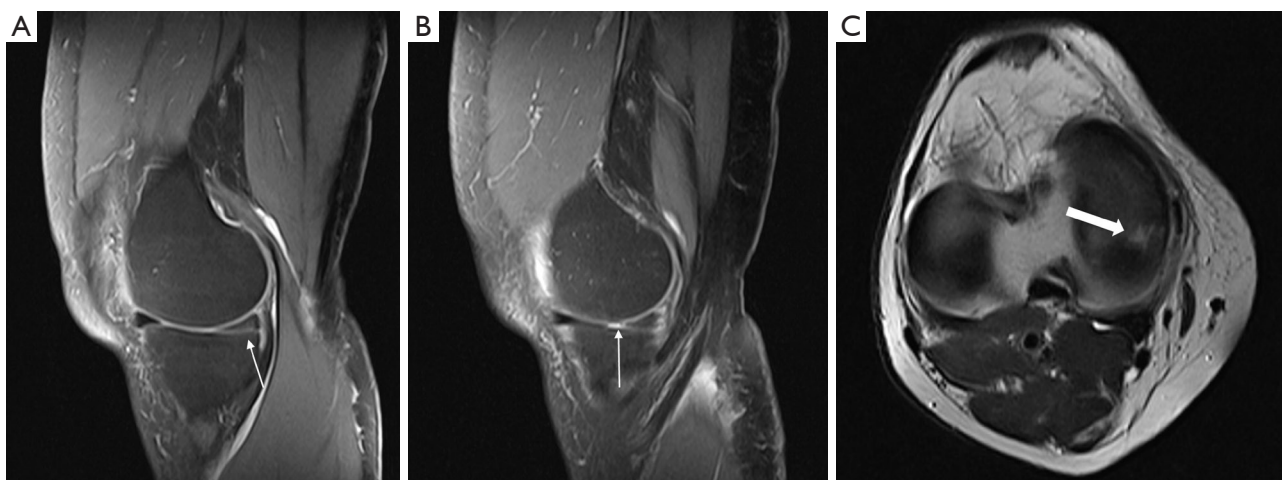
Degeneration of the posterior horn and a radial tear of the medial meniscus. (A) Sagittal PD-Fat sat image shows degeneration of the posterior horn of the medial meniscus (white arrow). (B) Sagittal PD-Fat sat and (C) axial T2-weighted images show a radial tear of the medial meniscus (white arrow). PD, proton density.
